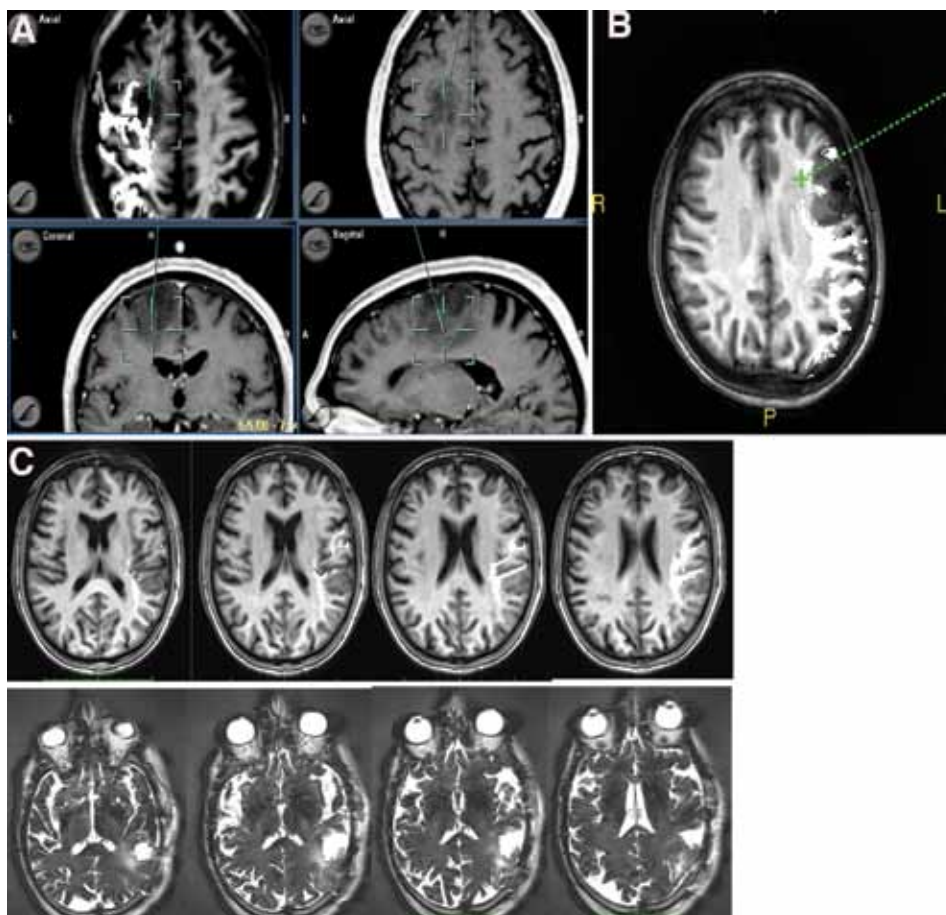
Diffusion tensor imaging–FT reconstruction of the SLF. A: A case of a left frontal F1, F2 Grade II oligodendroglioma. Diffusion tensor imaging–FT reconstructions of the SLF, highlighted as a *bright white ROI*, were fused with T1-weighted MR images. The tract constituted the lateral border of the tumor. Resection was performed with the aid of subcortical language mapping, which was continuously alternated with the tumor resection. Resection was stopped when language responses (phonemic paraphasias) were encountered. The intraoperative screen shots were taken where DES, performed in the site indicated by the center of the *green cursors*, identified such a response. B: A case of an F3 low-grade glioma. Diffusion tensor imaging–FT reconstruction of the SLF was fused with T1-weighted MR images. To visualize the portion of the tract located at the anterior and medial border of the tumor, an additional ROI was placed in the subcortical region of F3. Intraoperative DES induced phonemic paraphasias. The location of this site (*green cross*) was registered into the neuronavigation system at the time of surgery, as visualized by the intraoperative screen shot. C: A case of left temporal oligodendroglioma. Diffusion tensor imaging–FT reconstruction of the SLF was merged with T1-weighted MR images (*upper panels*). Postoperative T2-weighted MR images showed that the resection margins coincided with the location of the SLF (*lower panels*).
